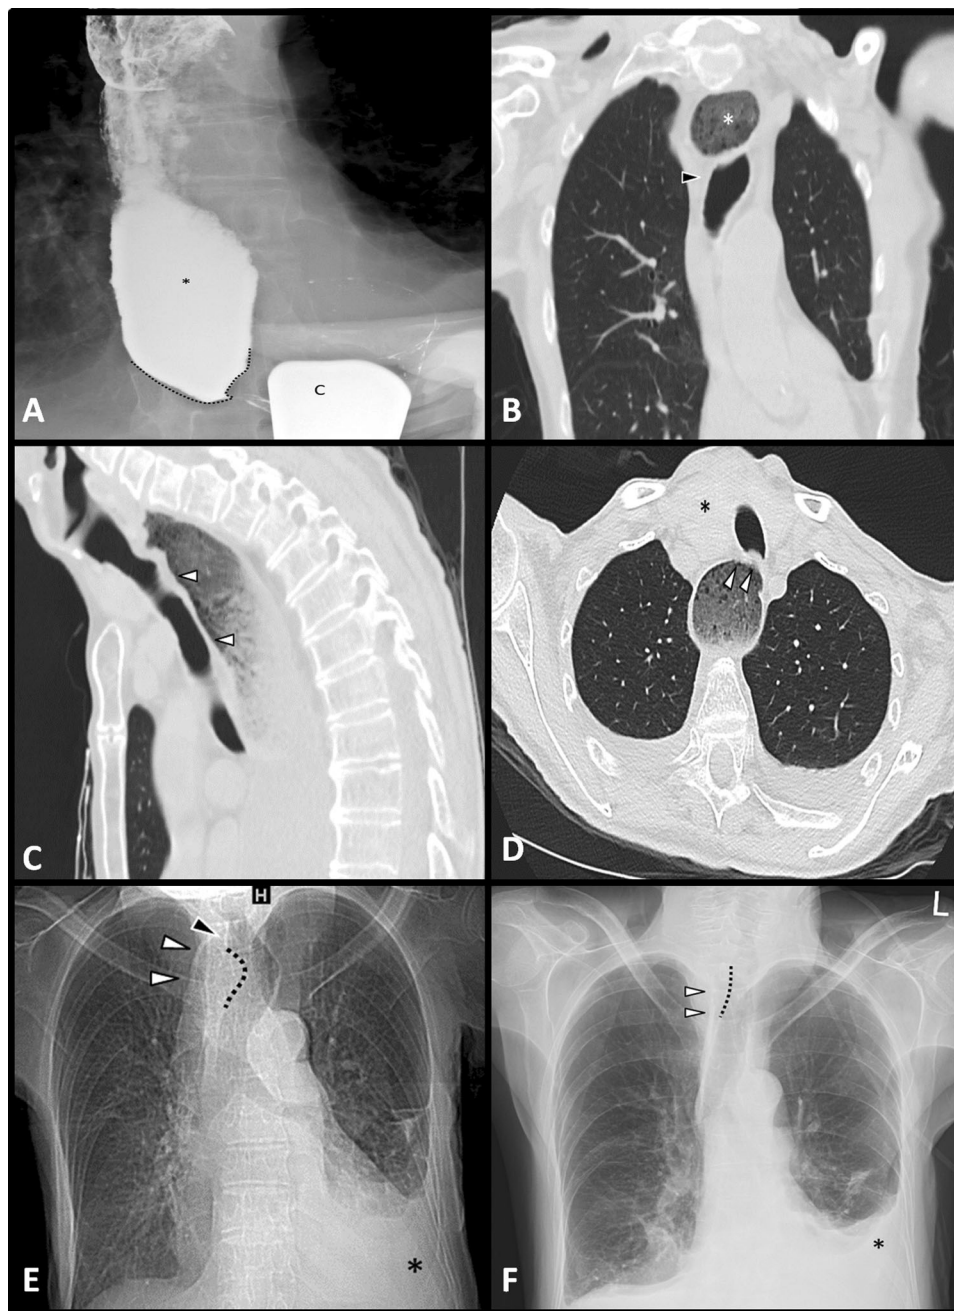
FIGURE A) A preoperative frontal posteroanterior chest radiograph taken during barium esophagography shows retention of barium within the lower esophagus (asterisk). Abrupt narrowing of the lower esophagus (dotted line) in keeping with achalasia (“bird’s beak sign”) is seen. The cup of barium (marked “c”) is included in the field of view, extrinsic to the patient. (B–E) Tracheal distortion shown in computed tomography images of the chest three days preoperatively. B) A coronal image in a lung window shows a patulous dilated esophagus filled with retained ingested contents (asterisk) resulting in leftward displacement of the trachea (black arrowhead). C) A sagittal image in a lung window shows anterior displacement of the trachea (white arrowheads) due to the dilated esophagus. D) An axial image in a lung window shows anterior and leftward displacement of the trachea (white arrowheads). There is also some mass effect on the trachea related to an enlarged right thyroid lobe/goiter (asterisk). E) Frontal scout showing a gas-filled structure along the right side of the upper mediastinum with convex borders (white arrowheads), in keeping with the dilated esophagus. There is a resultant mass effect on the trachea, which is displaced and bowed towards the left (dotted line). Abrupt angulation superiorly (black arrowhead) may represent the area of resistance to endotracheal tube advancement. A left pleural effusion is seen (asterisk). F) Frontal posteroanterior chest radiography one day following esophageal disimpaction shows midline positioning of the upper trachea with resolution of previously visualized leftward bowing (dotted line). The right lateral border of the esophagus is also more medially positioned and no longer appears convex (white arrowheads).
